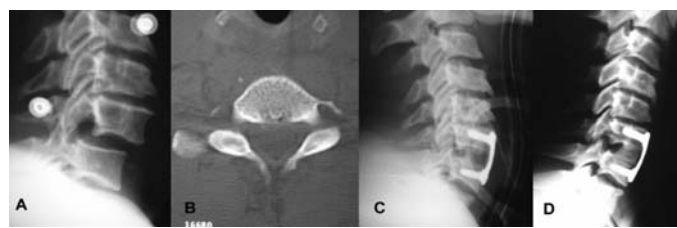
Patient number 17. (A) B1-type, Frankel E injury at C6-C7. (B) Computed tomography showing dislocation. (C) Reduction with traction halo and arthrodesis via anterior access. (D) Late postoperative control (3 years) showing subtle reduction loss not compromising clinical or functional outcomes.
